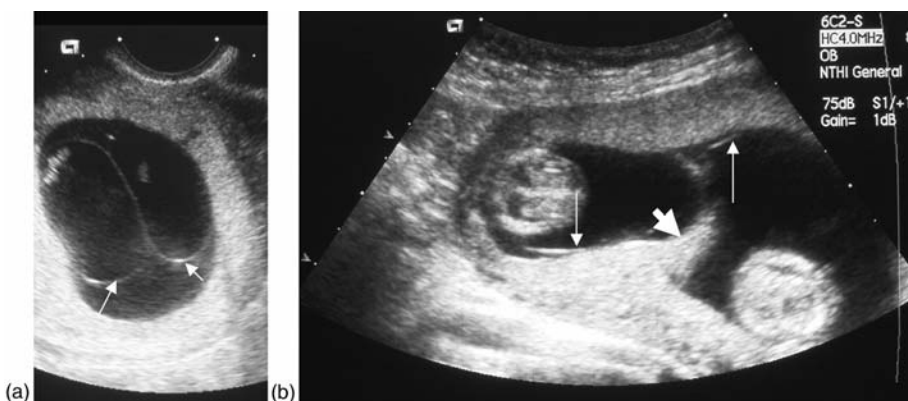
Chorionicity determination in the first-trimester ultrasound scan. (a) Monochorionic diamniotic twins: only two thin amniotic membranes (arrows) separate the two fetuses. (b) Dichorionic diamniotic twins: the fetuses are separated by three layers (amnion, chorion-chorion, amnion; arrows).
